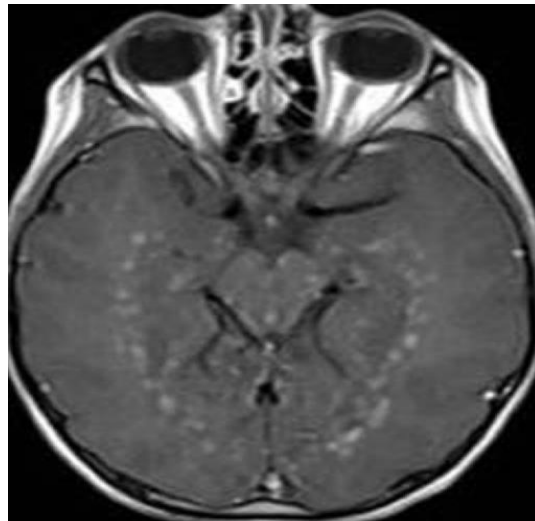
MRI T1W image shows multiple punctate lesions mainly around basal ganglia similar to our patient's findings. (Adopted from RadioGraphics^[3])
